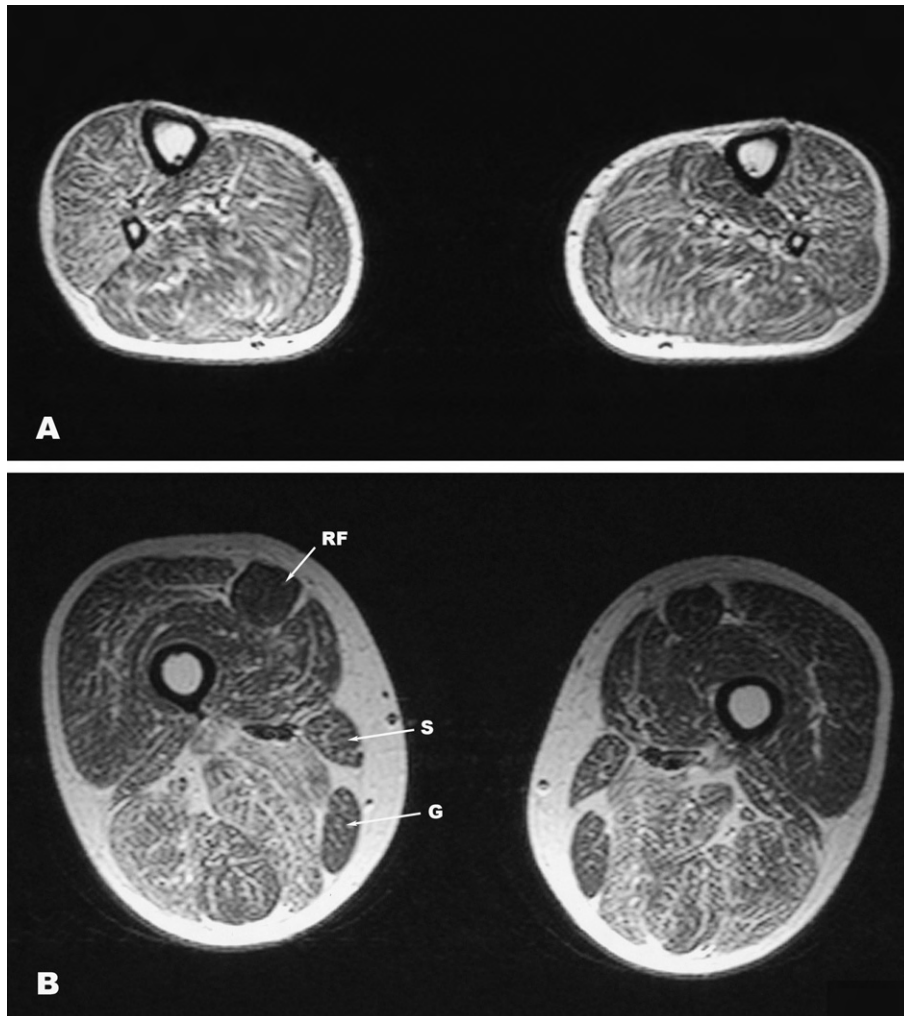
MRI of the lower legs and thighs of the patient. (A) Leg muscles: diffuse fatty infiltration of all muscles. (B) Thighs: diffuse fatty infiltration prevalent in the hamstrings with lesser involvement of the gracilis (G), sartorius (S) and rectus femoris (RF) muscles.
